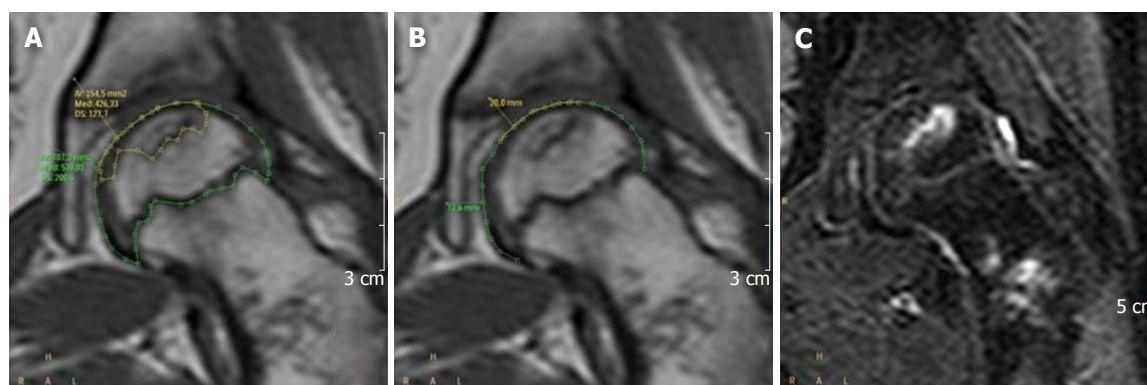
Assessment of relative volume and relative surface. The measurements were performed on a dedicated workstation on the T1-weighted images, both for RV (A) and RS (B) for each slice of the series. The corresponding STIR images (C) were reviewed in order to better evaluate the extent of the necrotic process. RV: Relative volume; RS: Relative surface; STIR: Short time inversion recovery.
